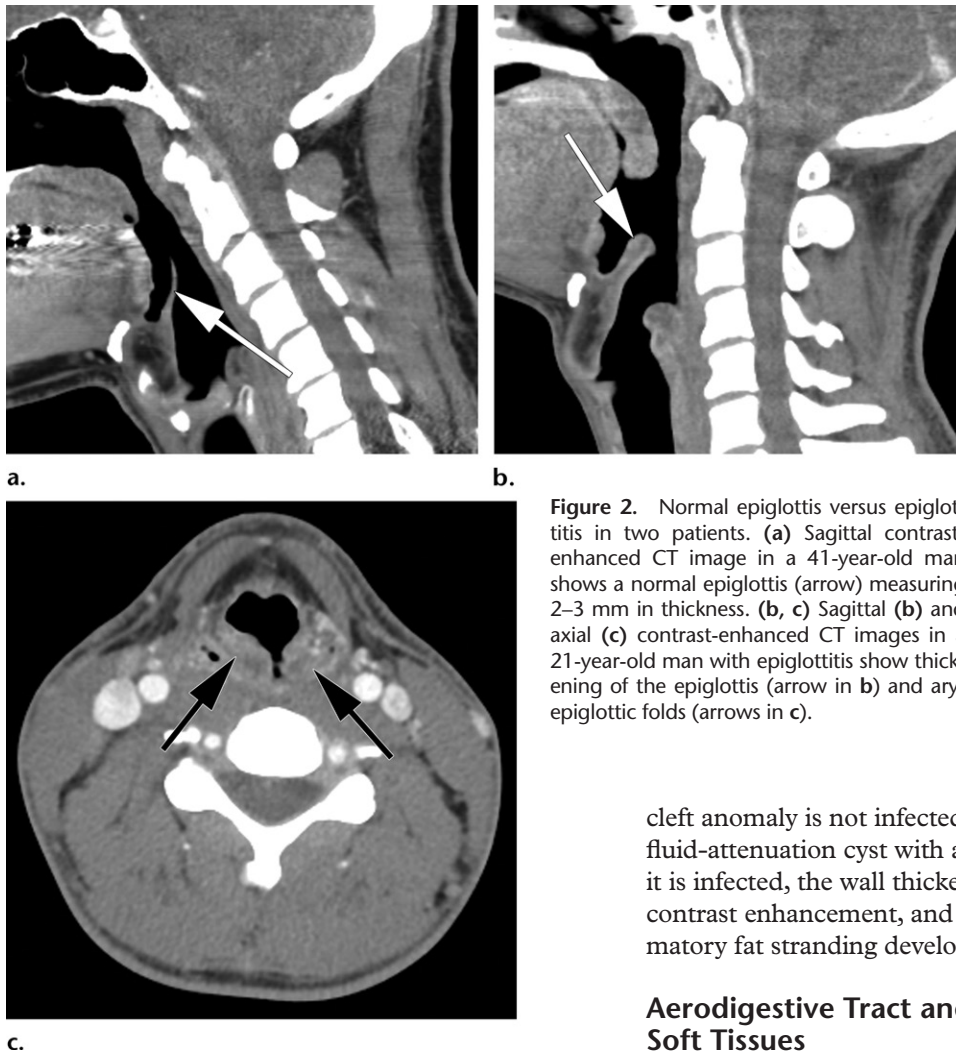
Normal epiglottis versus epiglottitis in two patients. (a) Sagittal contrast-enhanced CT image in a 41-year-old man shows a normal epiglottis (arrow) measuring 2–3 mm in thickness. (b, c) Sagittal (b) and axial (c) contrast-enhanced CT images in a 21-year-old man with epiglottitis show thickening of the epiglottis (arrow in b) and aryepiglottic folds (arrows in c).
